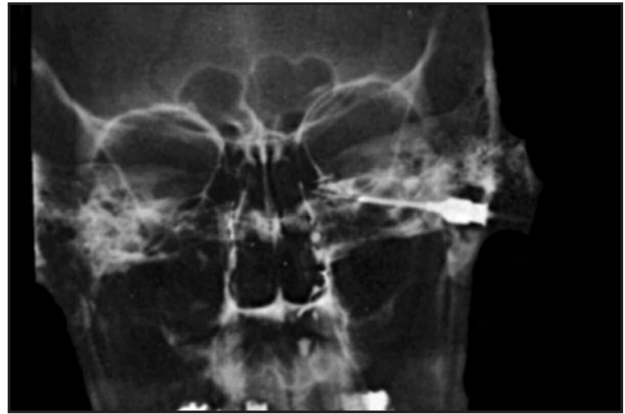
DCGF x-ray for the patient's left side. No complete obstruction, however, multiple filling defects can be seen throughout the lacrimal drainage system.
